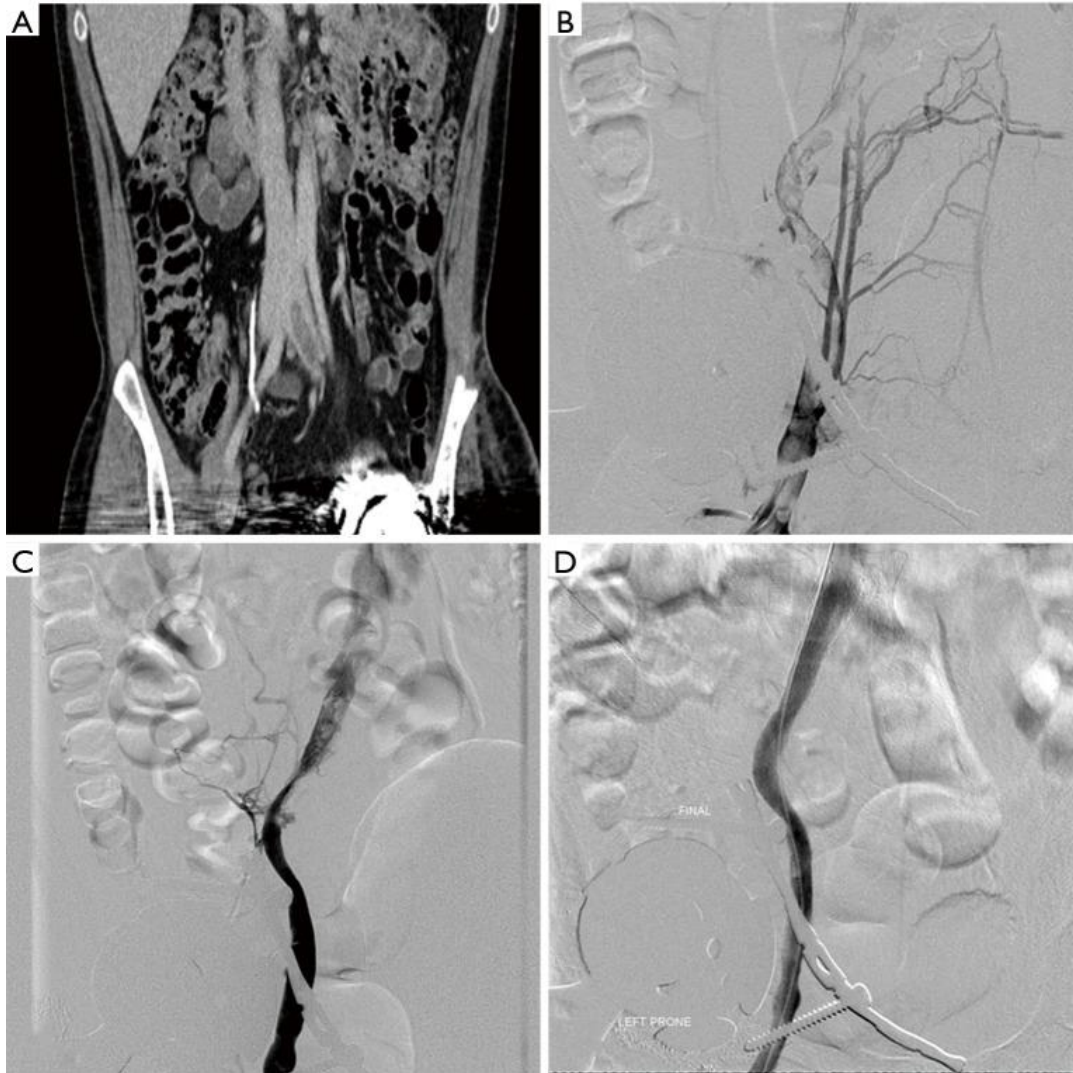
A) CT Abdomen and Pelvis demonstrating a portion of the DVT. B) Thrombolysis after placement of a temporary IVC filter. C,D) Mechanical thrombectomy followed by balloon angioplasty and stent deployment.
